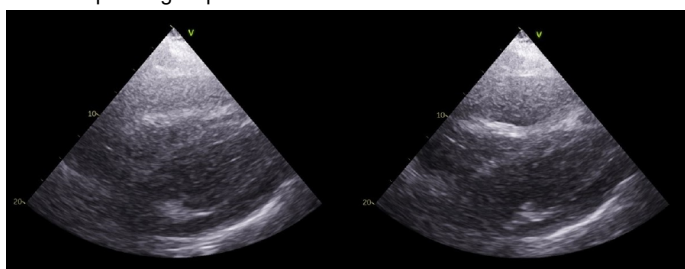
Transthoracic echocardiogram showing pericardial effusion with collapse of right cavities.
